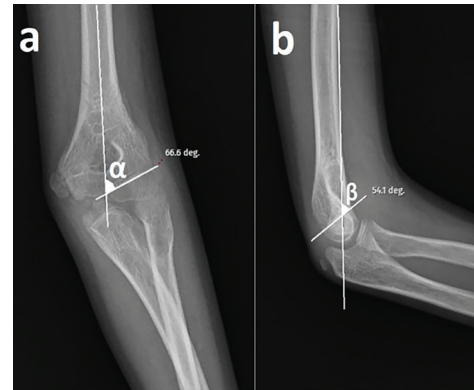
Anteroposterior (AP) and lateral elbow X-rays of the same patient taken at the 2-year follow-up. (a) Measurement of the Baumann angle on the AP elbow X-ray. (b) Measurement of the capitellohumeral angle on the lateral elbow X-ray
